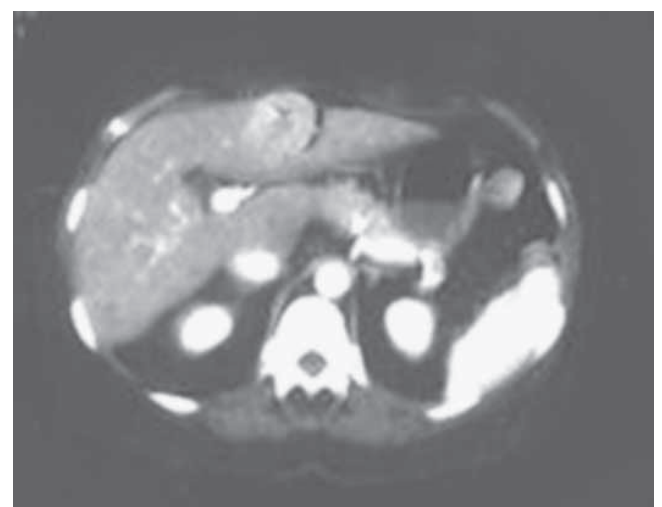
Computed tomographic scan shows a hypervascular hepatocellular carcinoma of the left liver.
